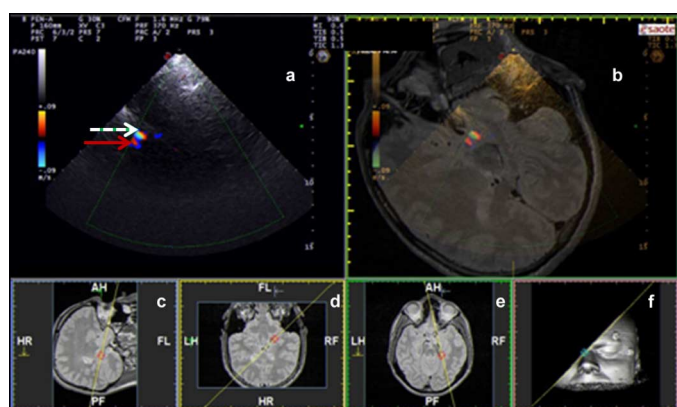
Example of Superior Petrosal Sinus (dotted arrow) and first segment of Rosenthal Vein (continuous arrow). (a) US fused with MRI; (b) MRI oblique plane; the vessel position is confirmed by the marker visualized on sagittal (c), coronal (d) and axial (e) views; (f) cut MRI rendering corresponding to the current US insonation plane.
